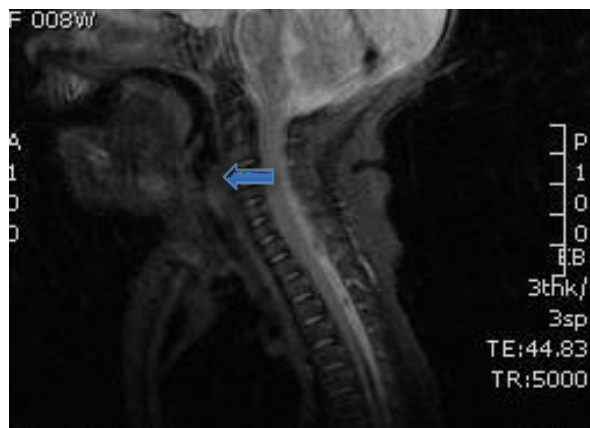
MRI finding: T2 hyperintense mass lesions showed by the arrows, most suggestive of haemangiomata. Lesions involved right parotid, parapharyngeal, submandibular, overlying manubrium sterni and also narrowing and mucosal hyperintensity of the subglottic airway which likely represents further haemangioma, although imaging of this lesion is suboptimal
